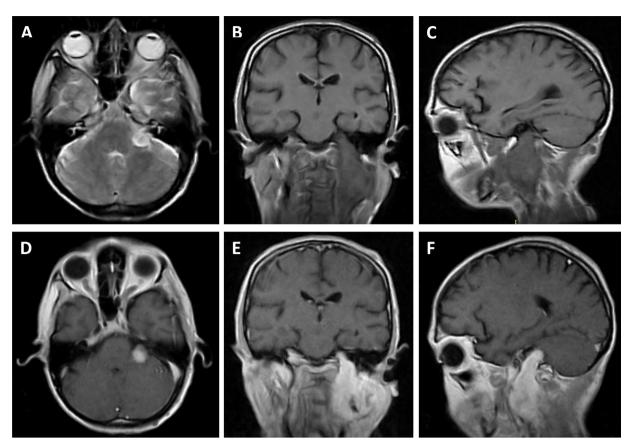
Preoperative brain MRI showing a hyperintense neoplastic lesion on T2 sequence at left cerebellopontine cistern (A) with extension to C4-C5 level through jugular foramen (B and C), it enhances at gadolinium administration (D–F) and shows a low signal intensity in the center (E and F).
